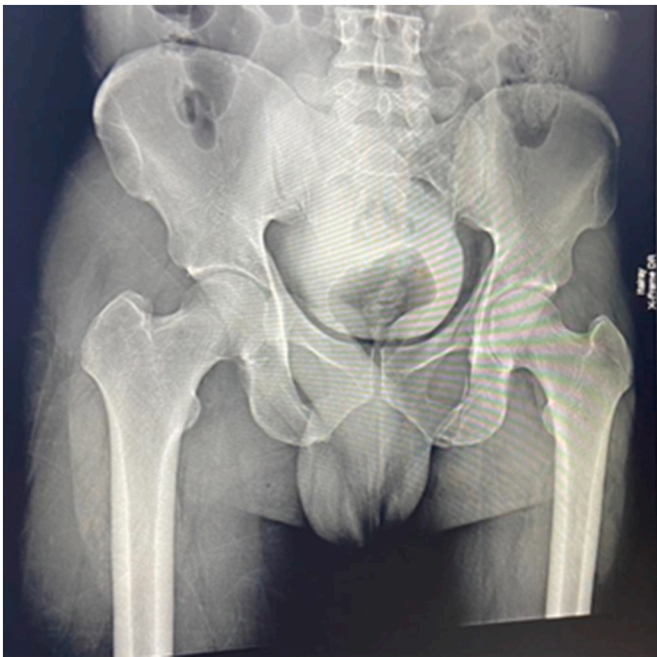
Case 1: X-ray of the control pelvis showing the head of the femur in place of the acetabulum, without bone lesion.
